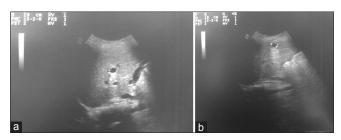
(a and b) Abdominal ultrasonography showing two small hepatic cysts
